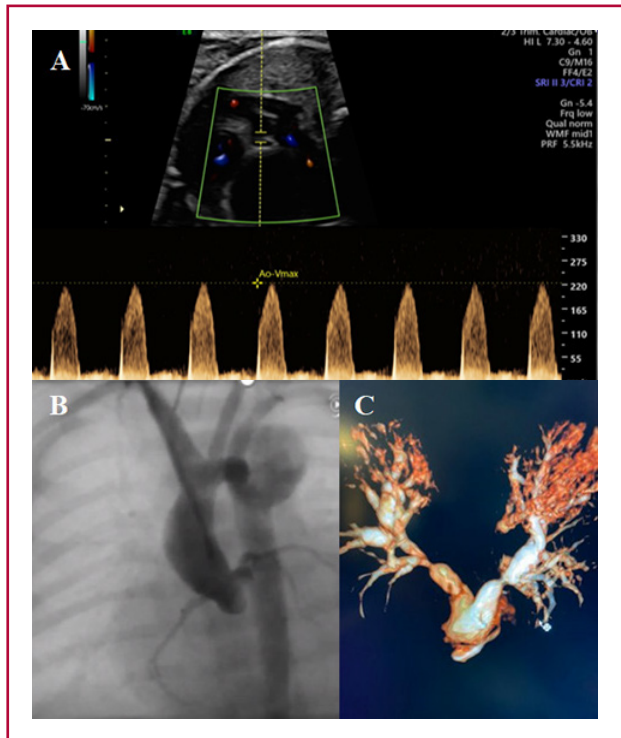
Doppler echocardiography showing critical aortic stenosis (A). Angiography through carotid access post aortic valvuloplasty (B). Angiographic reconstruction of surgical cerclage in both pulmonary branches (C).
